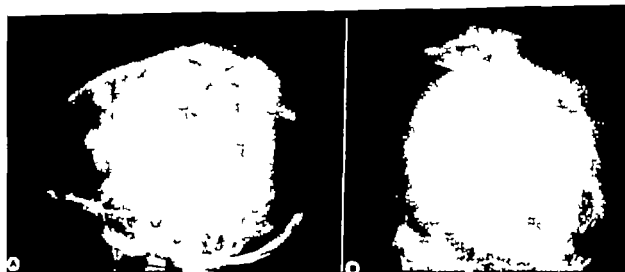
An unusual manifestation of secondary involvement of the skull by a meningioma. This was mistaken elsewhere for fibrocystic disease and treated with x-rays. The tables are expanded, thinned, and partially destroyed. Though most of the lesion appears cystic, the radiating spicules can be seen along portions of both tables.
